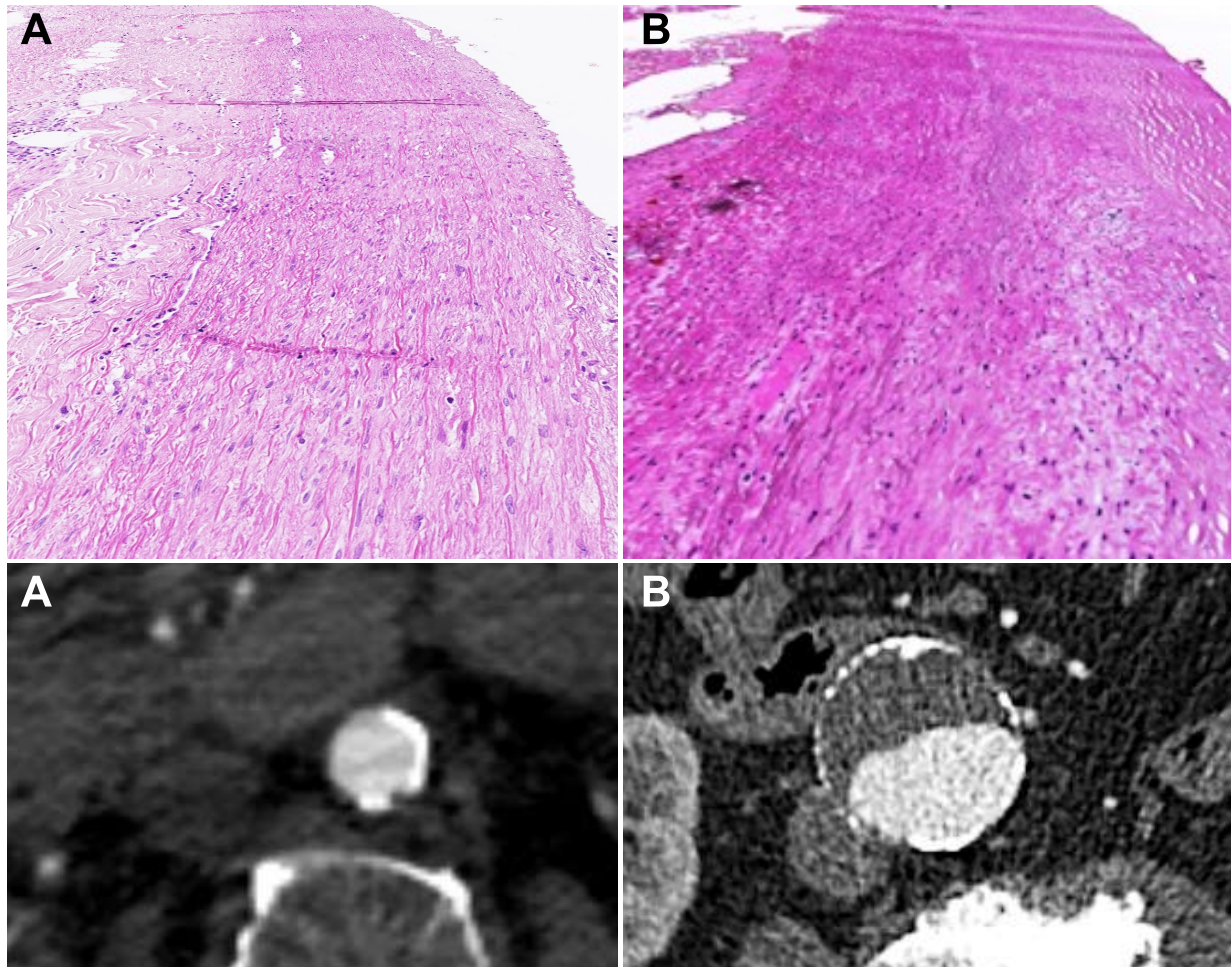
Comparison of normal aorta and AAA: The non-aneurysmatic infrarenal aorta (A) has a contained structure with approx. 28 layers of elastic fibers with VSMC in between (upper row). No intraluminal thrombus (ILT) and some calcification of the aortic wall is seen on CT-angiography (lower row). In AAA (B), the aneurysm wall shows a more diffuse organization of the layers with less cells and more extracellular matrix content (upper row). On CT, the circumference is unevenly covered with ILT (lower row). (source: own material from laboratory and clinical unit)
